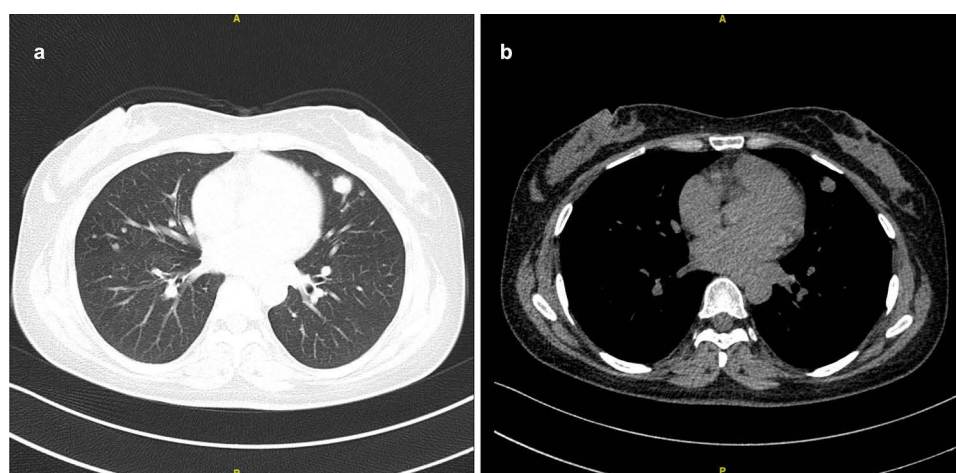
Chest computed tomography findings. (a) Lung-window axial CT image showing multiple bilateral pulmonary nodules, including the largest nodule in the lingula of the left upper lobe. (b) Mediastinal-window axial CT image showing the same lesion. The largest lesion measured approximately 13.5 mm × 12.2 mm.
